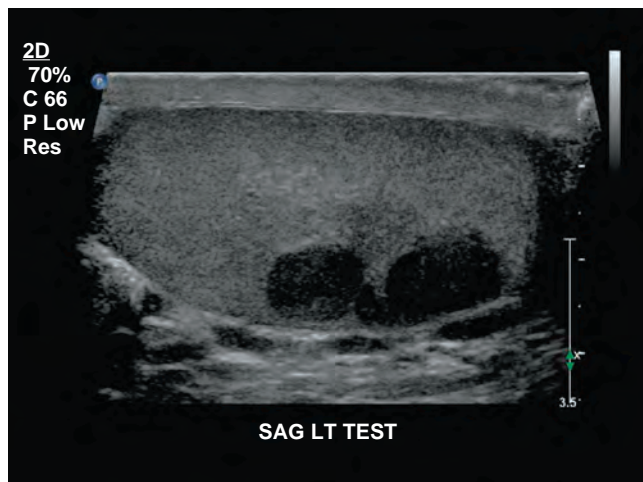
Sagittal view of ultrasound of left testis showing multi-nodular hypoechoic intratesticular lesion confirmed to be pure seminoma at orchiectomy.
